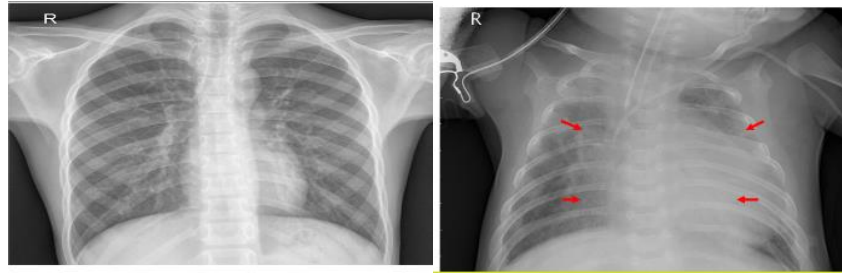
Examples of two x-ray images (a) healthy lung and (b) pneumonic lung
